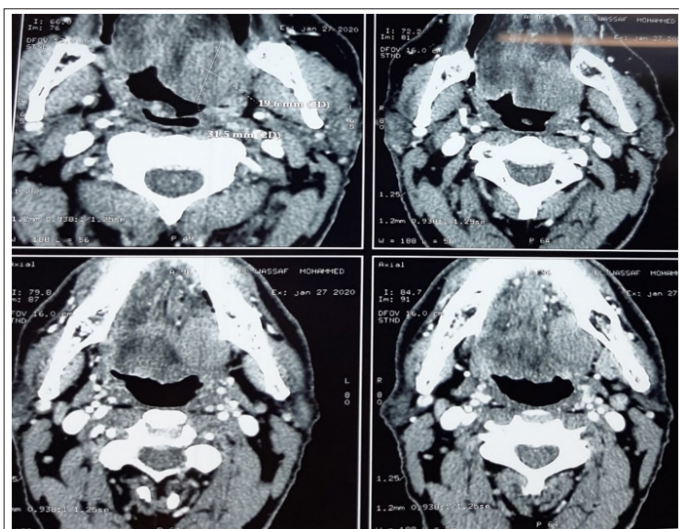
CT Scan Showing Voluminous Tissue Process of the Left Posterolateral Part of the Base of the Tongue Protruding into the Oropharynx and Establishing Close Contact with the Mylohyoid Muscle
